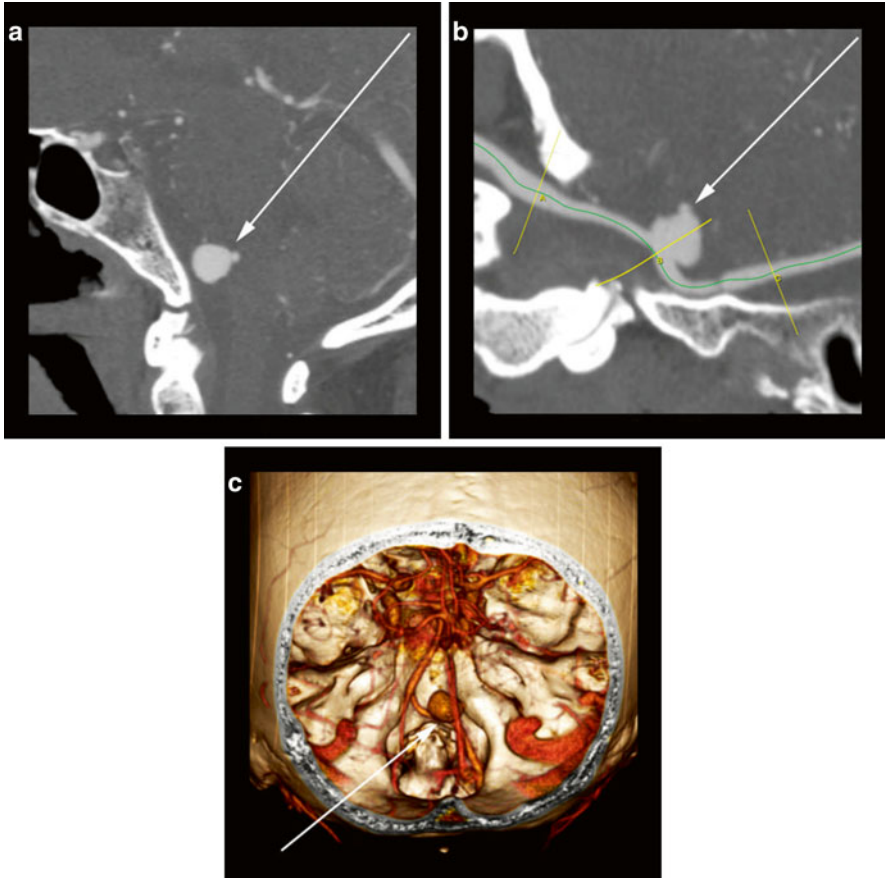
91-year-old male with V4 segment vertebral artery aneurysm. (a) Sagittal CTA image reveals an irregularly shaped aneurysm in the region of the right vertebral artery with focal out-pouching “nipple” (*arrow*) off of the posterior aspect. (b) A stretched curved MPR CTA reformat better depicts the orientation of the aneurysm (*arrow*) to the parent vessel. (c) Posterior oblique 3D volume rendering of the CTA data provides another assessment of the aneurysm orientation (*arrow*) to the parent vessel and surrounding bones
